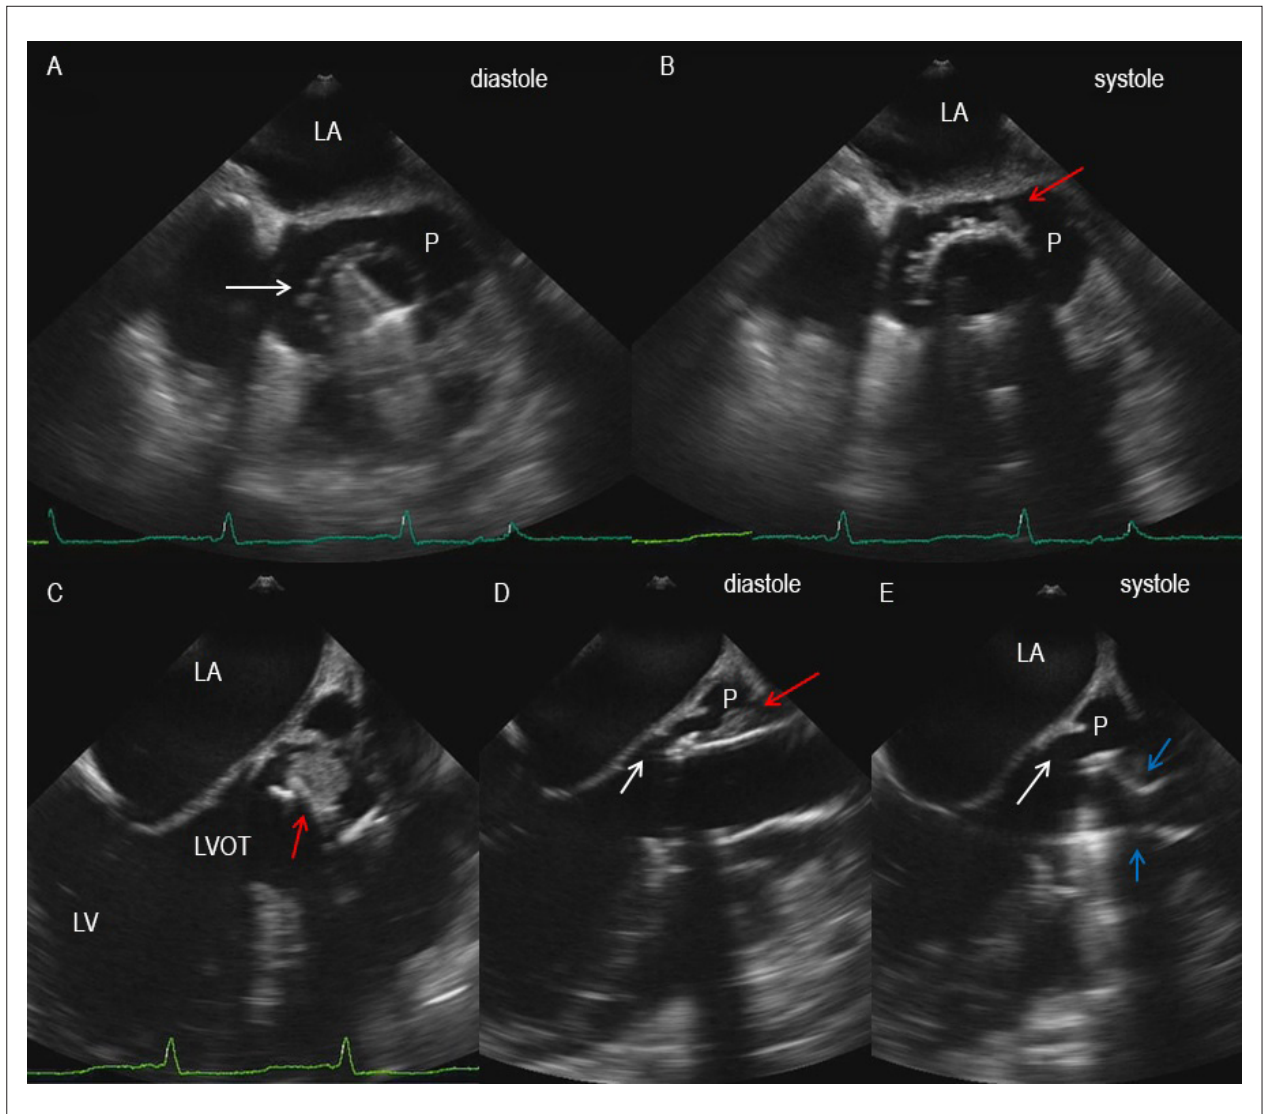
Transesophageal echocardiogram. Panel A: Dehiscence of the aortic valve conduit with a giant pseudoaneurysm in the ascending aorta wrapping the conduit (white arrow). Panel B and C: Aortic periannular vegetation (red arrows). Panel D (diastole) and E (systole): During systole, valve conduit was pushed by the systolic pressure and it produced a vertical movement of the prosthetic valve (“rocking valve” image) with complete folding of the conduit (blue arrows). P: pseudoaneurysm; LVOT: left ventricular outflow tract; LA: left atrium; LV: left ventricle.
